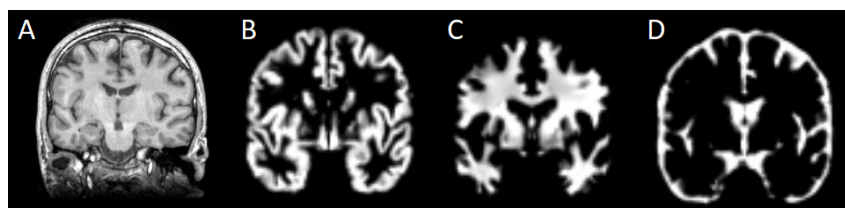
Tissue segmentation and normalisation to standard space in T1-weighted structural MRI pre-processing. Raw T1-weighted images (A) display considerable anatomical variation between subjects. Co-registration and normalisation aligns subject anatomy with standard MNI space, and produces tissue segments of (B) grey matter, (C) white matter and (D) cerebrospinal fluid (CSF).
